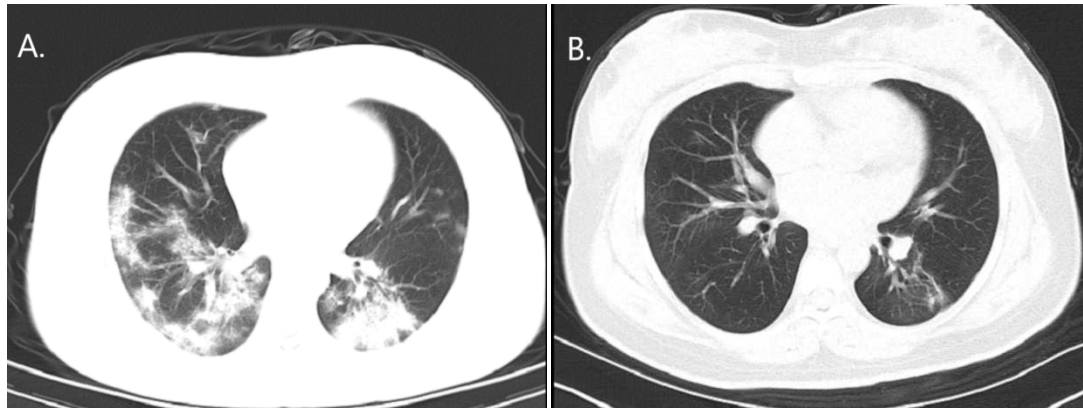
Chest CT image of pregnant patients diagnosed with COVID-19
